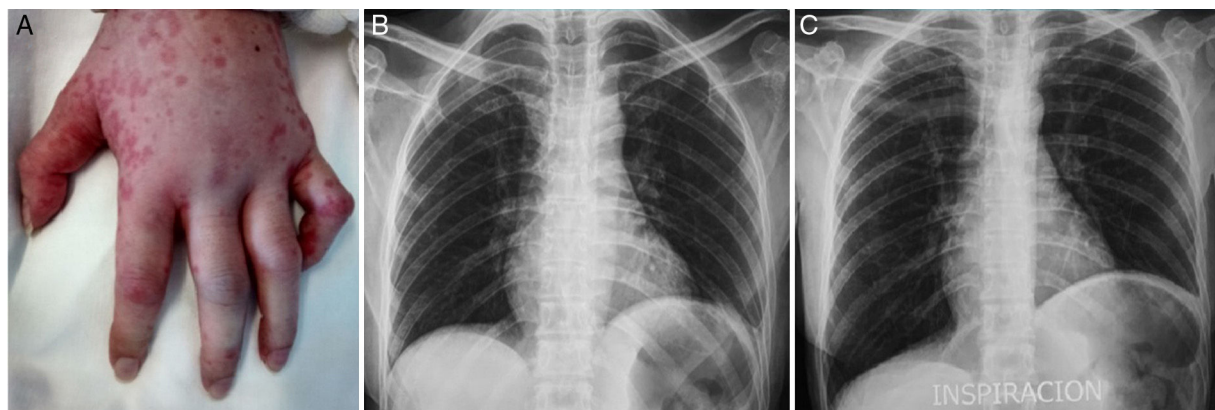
(A) Edema and urticaria in the patient's left hand and flexion of the fifth finger produced by involvement of the ulnar nerve. (B) Chest radiograph during exhalation. (C) Chest radiograph during inhalation showing hemiplegia affecting left hemidiaphragm.
